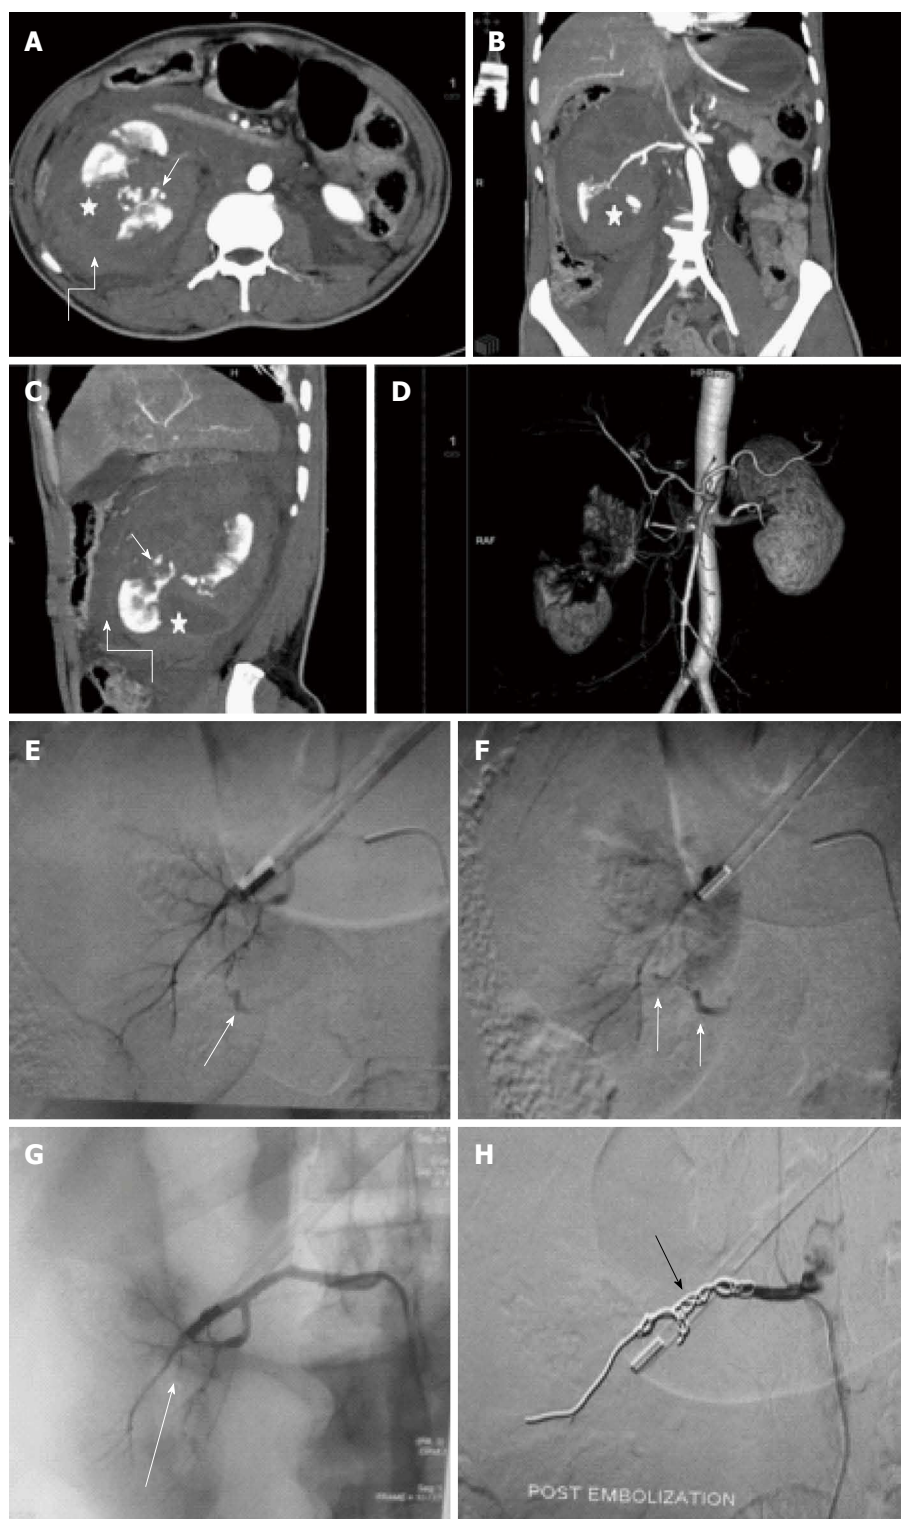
Main renal artery injury. A-D: CECT in a 22 years old male following road traffic accident revealed multiple deep lacerations (asterisk) involving entire thickness of right kidney resulting in shattered kidney. Few areas of active contrast extravasation (thin arrow) were noted at the edge of laceration along with presence of extensive perinephric hematoma (curved arrow). Although, main renal artery was showing good luminal opacification, however, less than 25 % remaining functioning renal parenchyma precluded salvagability. Due to high post operative morbidity, angiography was resorted over nephrectomy; E, F: Selective catheterisation of main renal artery showed multiple areas of active contrast extravasation (arrow); G: Subsequently, in view of potentially life threatening haemorrhage and non-salvageable kidney, coil embolization (arrow) of main renal artery was contemplated; H: Post embolization angiography showed opacification of only proximal stump of renal artery. Following conservative management, patient was then discharged 8 d later. CECT: Contrast enhanced computed tomography.
